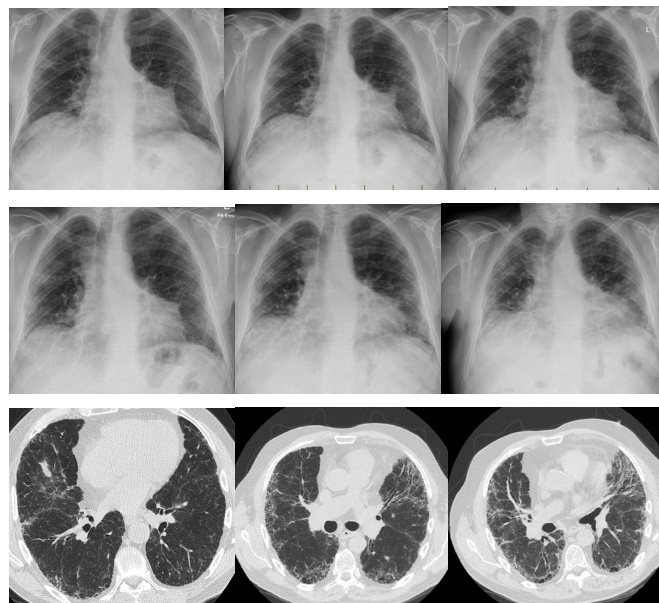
b. Chest X-Ray and CT Scans for patient B, showing progressive changes in the interstitial opacity
